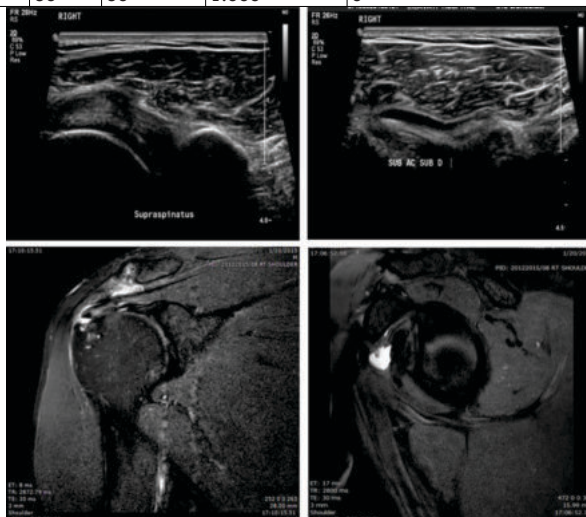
(a,b) USG images in transverse and oblique showing full thickness tear of supraspinatus tendon with fluid in sub-acromion, sub-deltoid and sub-coracoid bursa, (c,d) MRI coronal and sagittal images showing the same.
